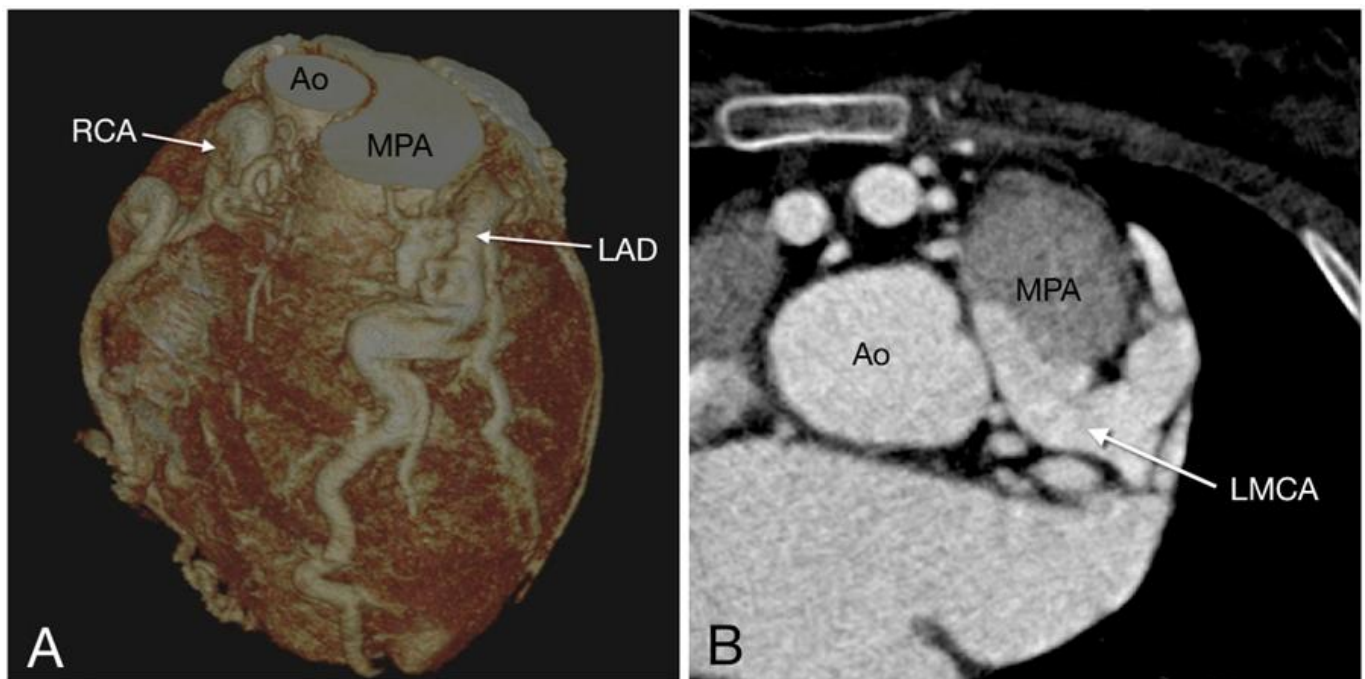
Coronary CT of a young patient with anomalous left coronary artery from the pulmonary artery (ALCAPA or Bland-White-Garland syndrome). Prior echocardiographic examination showed findings suspicious for coronary fistula. A, volume rendered image showing tortuous and dilated coronary arteries. B, axial image shows the left main coronary artery arising from the main pulmonary artery with reflux of contrast into the latter suggestive of reversal of flow. No significant stenosis or coronary fistula identified in this examination. Ao = aorta, MPA = main pulmonary artery, LMCA = left main coronary artery, LAD = left anterior descending coronary artery, RCA = right coronary artery.
